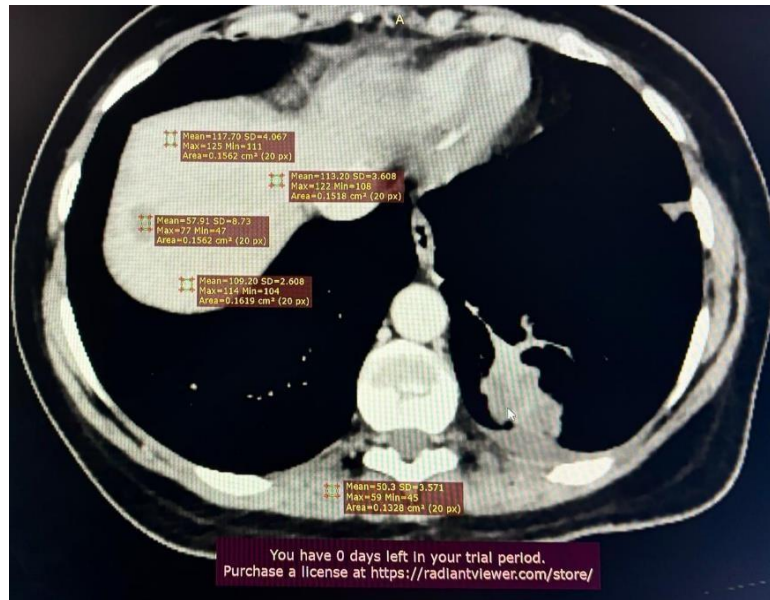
Axial view for liver CT scan for a patient with metastatic liver disease.
